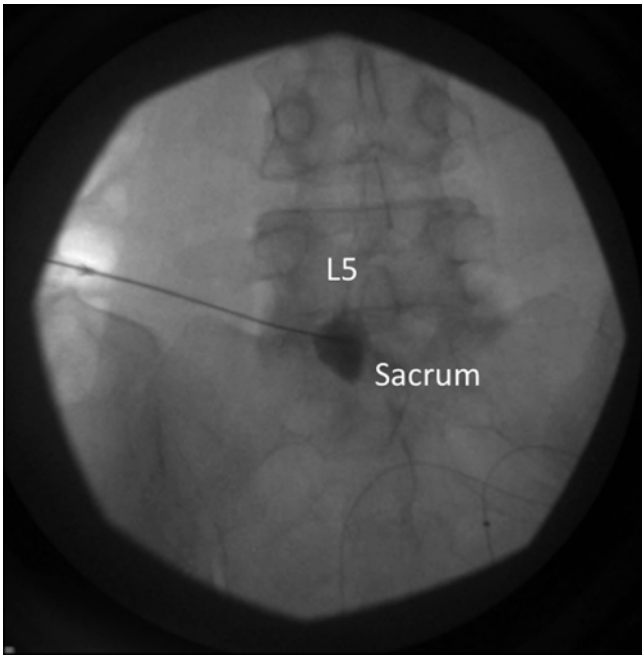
Anteroposterior radiograph of the lumbosacral junction. The needle was seen inserted to the anterior aspect of the lumbosacral junction with contrast confirmation (With permission from Philip Peng)
